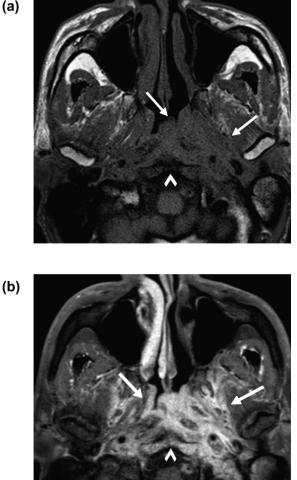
a. Axial MRI TI-weighted noncontrast image demonstrates abnormal soft tissue, isointense to muscle infiltrating submucosally into the nasopharyngeal tissues and surrounding the left cervical ICA (white arrows). T1 hypointense marrow signal is again seen within the clivus (arrowhead). b. Contrast-enhanced axial T1 weighted image with fat saturation demonstrates marked enhancement within the infiltrative tissue (white arrows) and underlying clivus (arrowhead).
